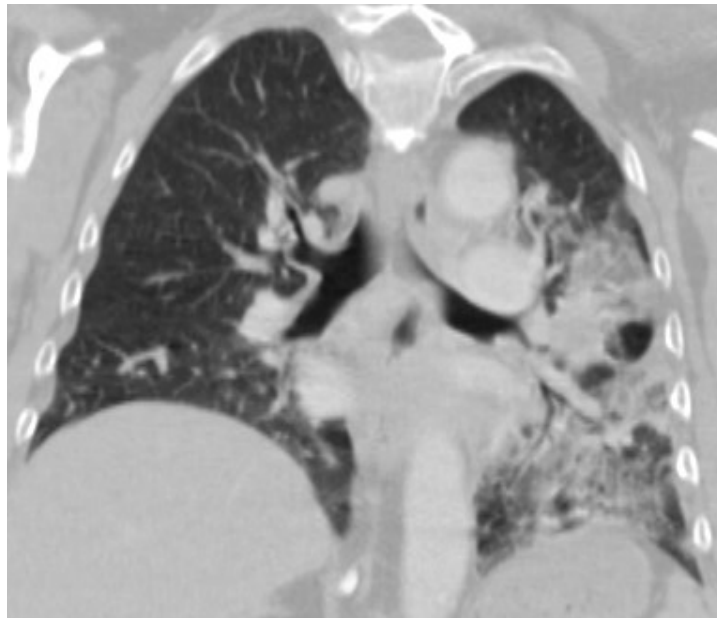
Initial CT at the level of the left hilum showed large left hilar mass 3.9x3.5x4.9cm in her left lung. Left lower lobe mass was 2.4cmx2.9cm and multiple nodules were seen on the left. A lytic lesion was seen in the humeral head.
